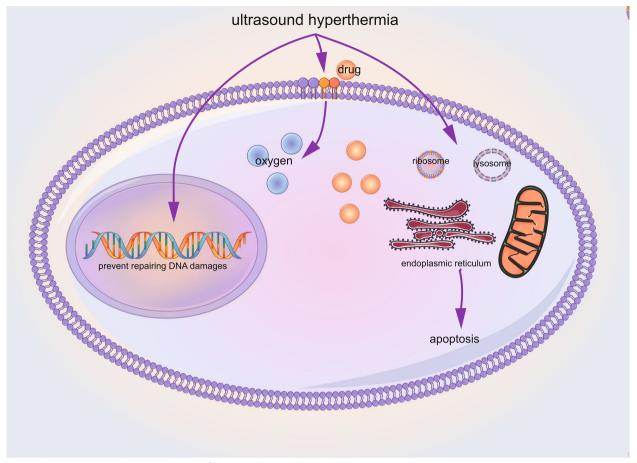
The anti-cancer regulation mechanism of ultrasound hyperthermia
